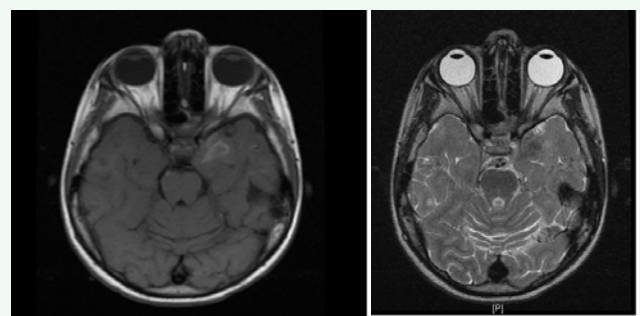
MRI of the brain (panel A axial, T1, panel B axial T2) revealed enhancing architectural distortion of the left temporal lobe and foci of dural enhancement.
